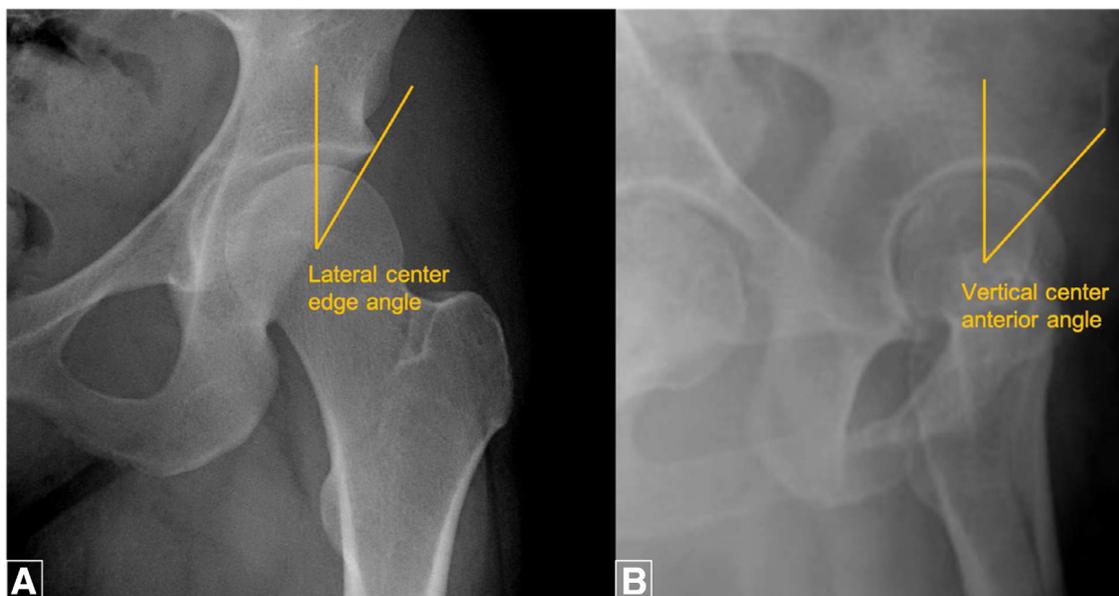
(a) Lateral center edge angle (CEA), on AP radiograph of the hip, a vertical line through the center of the femoral head and another through the center of the head and lateral edge of the acetabulum (Normal CEA is 25° - 40° , abnormal $<20^{\circ}$). (b) Vertical center anterior angle (VCA), on false profile view of the hip, a vertical line through the center of the femoral head and a line from the center of the femoral head to the anterior edge of the acetabulum (Normal VCA is 25°).
